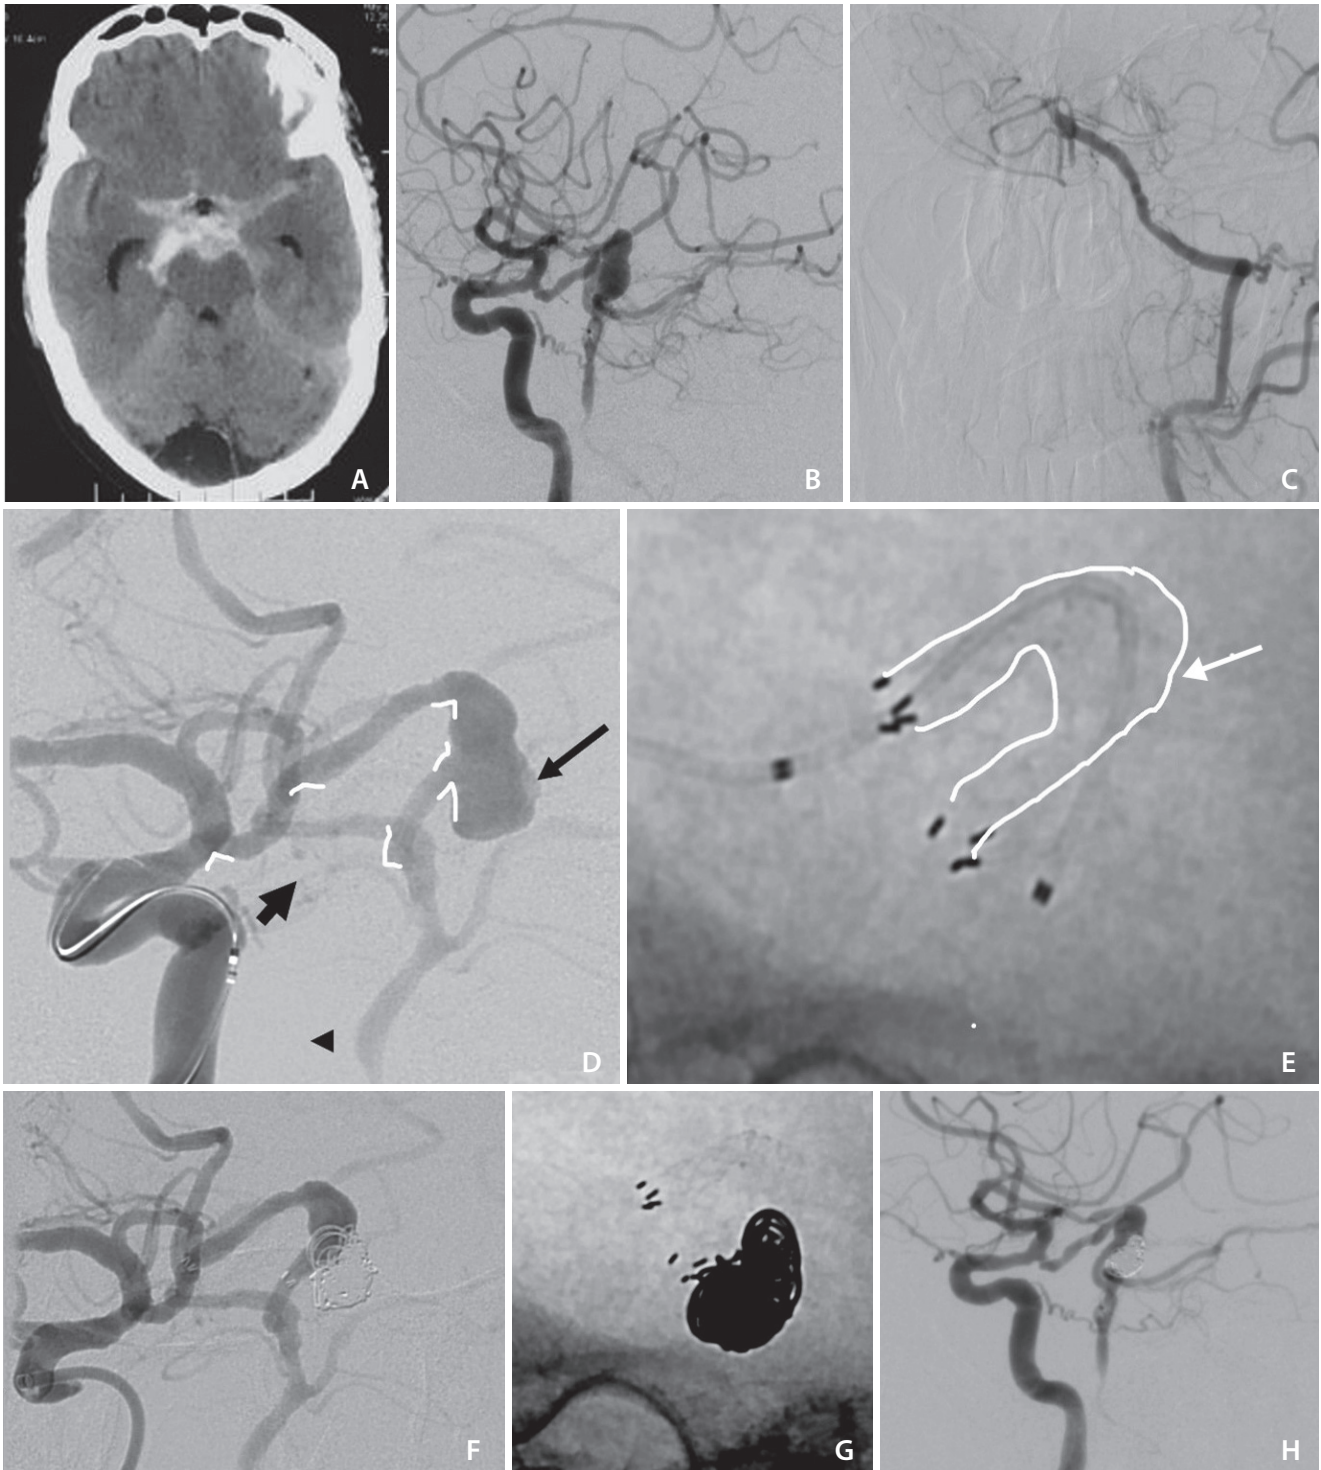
A patient with sudden onset severe headache. (A) Brain CT showing diffuse subarachnoid hemorrhage. (B) Right internal carotid angiogram showing acutely ruptured fusiform aneurysm of the PCoA in its middle and posterior third junction with reformation of the basilar artery through the PCoA. (C) Left vertebral angiogram shows proximal basilar occlusion. (D) Right ICA angiogram show the morphology of the fusiform true PCoA aneurysm with extreme tortuosity in its entire course (arrows and arrowhead). (E) Plain radiograph in lateral view. The deployment was completed with good positioning of the stent and being a 4.5 mm stent there was a good opening of the stent in proximal fusiform segment of the aneurysm (stent outlined in white, white arrow). (F) Post-stenting angiogram showed good flow in the reformed basilar artery and its branches. (G) Plain radiograph in lateral view showing the coil mass and the stent. (H) Final right ICA showing complete exclusion of the saccular component of the sacculofusiform aneurysm and good flow in the reformed basilar artery. CT, computed tomography; PCoA, posterior communicating artery; ICA, internal carotid artery.
